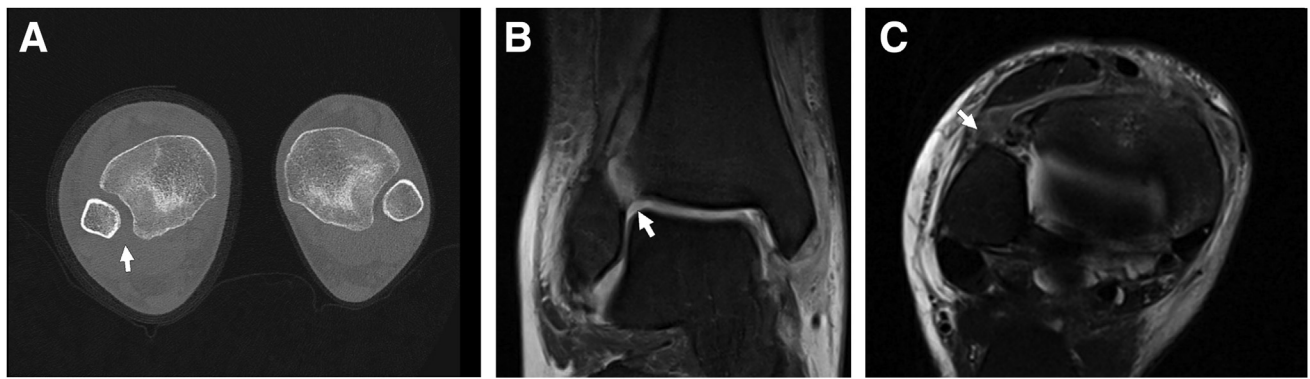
Images show grade III syndesmosis injury in a right ankle. (A) Axial computed tomography views of both ankles showing an increased tibiofibular space in the right ankle (arrow). (B) Coronal magnetic resonance imaging view showing edema in the anterior inferior tibiofibular ligament (arrow). (C) Axial magnetic resonance imaging view showing anterior inferior tibiofibular ligament injury from its fibular attachment site.
